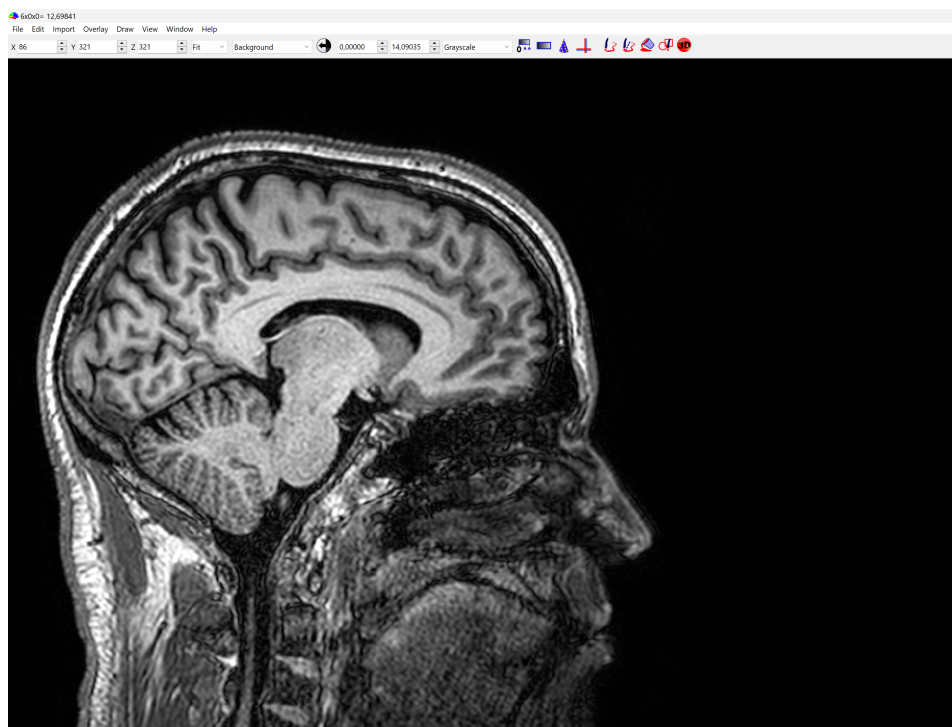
Screenshot taken during the use of MRICron for MRI visualization purposes.
